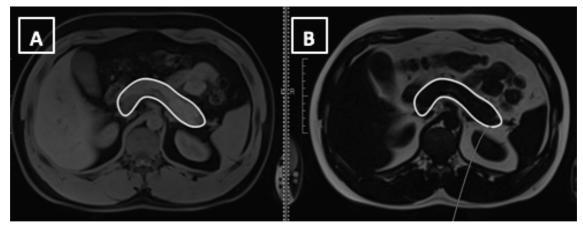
Location of the pancreas on corresponding water (A) and fat (B) axial MRI images.
